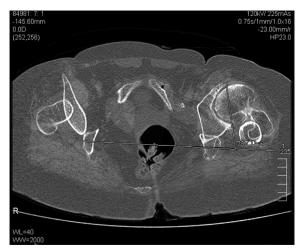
Computed tomography scan used for preoperative planning
